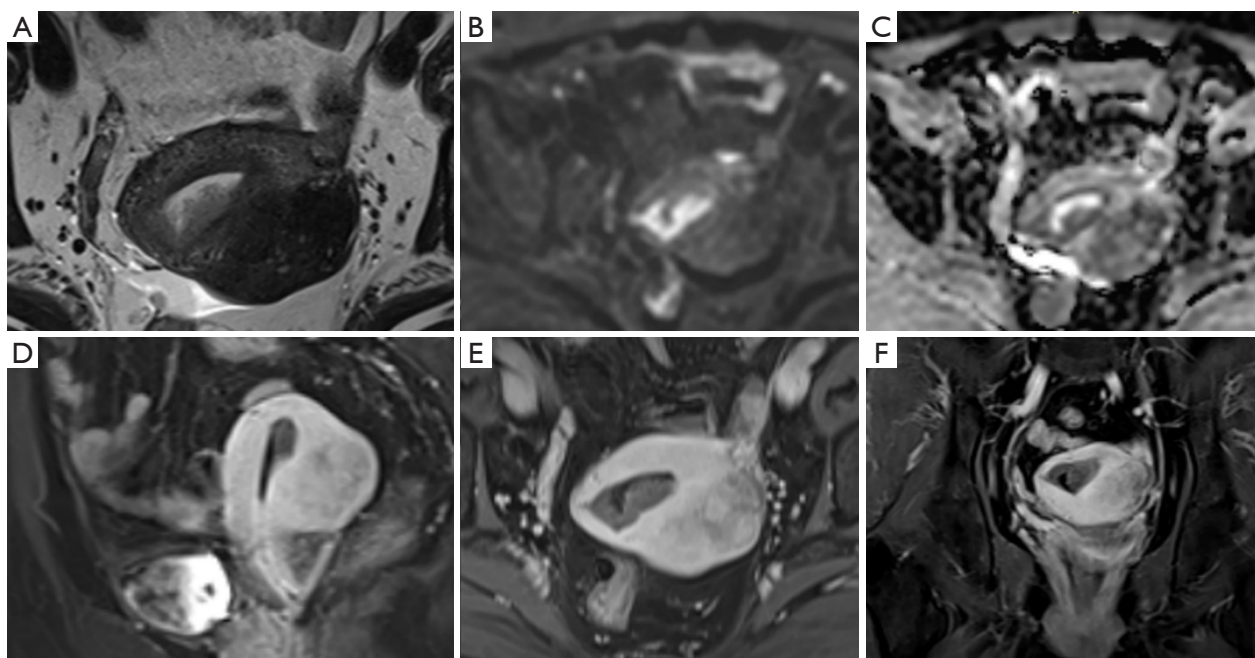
A 60-year-old patient with an endometrioid cancer (G1) coexisting adenomyosis and surgical pathology confirmed FIGO stage IA. (A) axial oblique T2WI, (B) axial diffusion weighted ($b=1,000 \text{ s/mm}^2$), (C) axial apparent coefficient diffusion map, (D) sagittal delayed-phase T1CE MRI scan 150 s after gadolinium chelate injection, (E) axial oblique delayed-phase T1CE scan 180 s after gadolinium chelate injection, and (F) coronal delayed-phase T1CE scan 240 s after gadolinium chelate injection. Adenomyosis was located in the outer myometrium of the corpus uteri and is not adjacent to endometrial cancer foci. And adenomyosis did not affect the identification of the depth of myometrial infiltration in this case. G, grade; FIGO, International Federation of Gynecology and Obstetrics; T2WI, T2-weighted imaging; T1CE, T1-weighted contrast-enhanced; MRI, magnetic resonance imaging.
